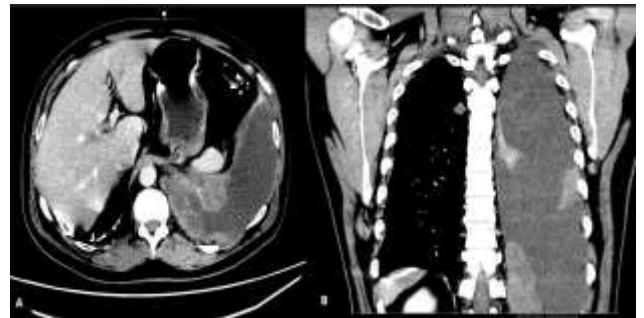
Contrast enhanced CT chest axial (A) and coronal (B) images showing heterogeneously enhancing nodular pleural thickening consistent with biopsy proven meningioma mets
